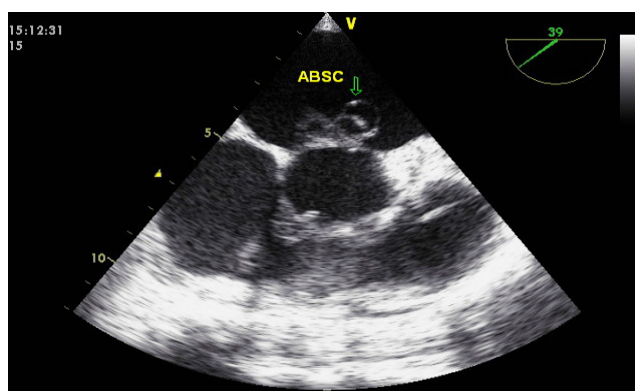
Transesophageal echocardiography, cross-sectional view, with visualization of lesion in the mitral valve, below the aortic valve.
